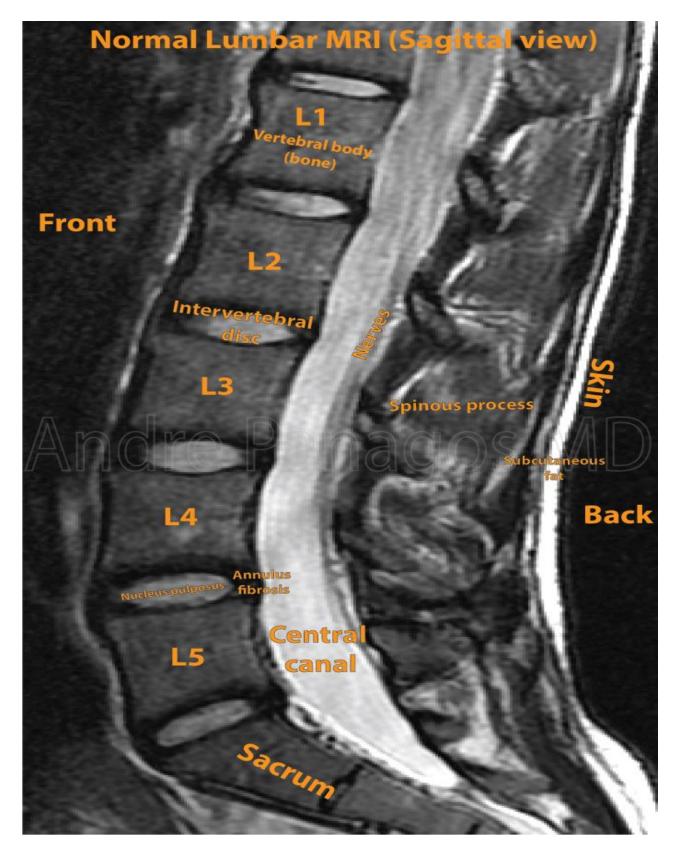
Normal Lumbar MRI; Sagittal view
